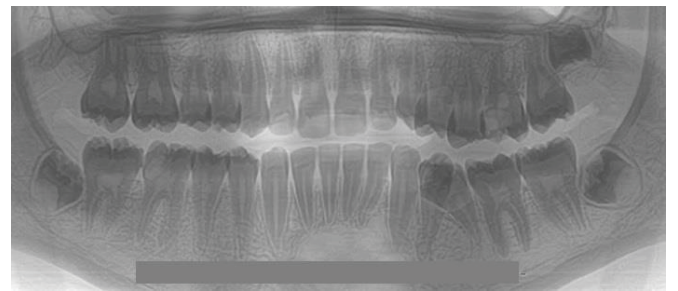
Panoramic X-ray showing the unilocular cyst between 22 and 28 dental elements.
